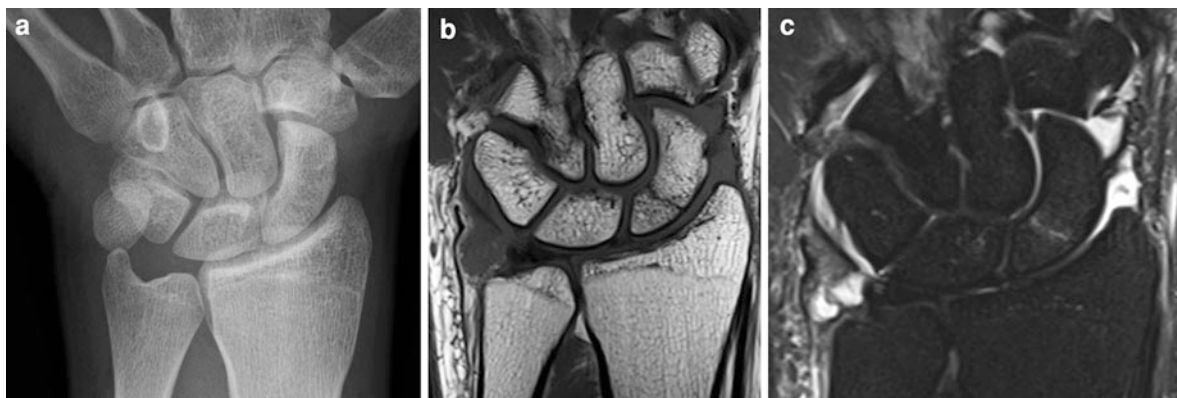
a Radiographs are normal. No scaphoid fracture identified on any view. b and c Coronal T1-weighted and STIR MR demonstrates a fracture across the scaphoid waist
